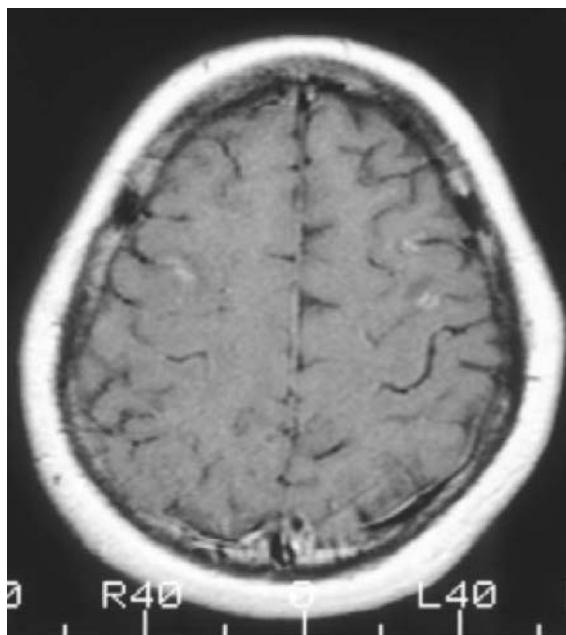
Contrasted MRI in NPSLE. This T1-weighted gadolinium contrasted MRI demonstrates multiple areas of enhancement indicating focal blood-brain barrier breakdown consistent with active NPSLE.
